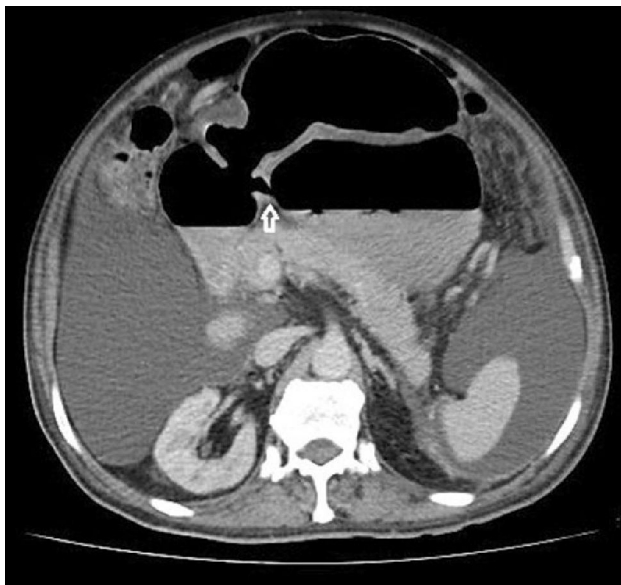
Contrast enhanced CT axial section showing gastric diverticulum in the lesser sac communicating with gastric antrum (white arrow).
